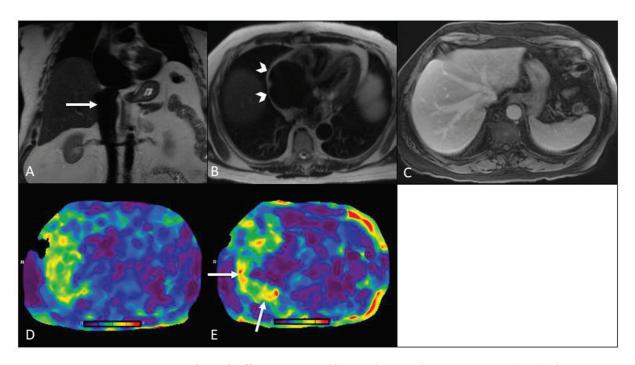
Passive venous congestion causing elevated stiffness. A 70-year-old man with tricuspid regurgitation. T2W (A, B) and postcontrast T1W (C) images show dilated IVC (arrow in A), right atrium (arrowheads in B) and dilated hepatic veins (C). MRE (D, E) shows elevated stiffness (mean 3.9 kPa). Notice predominantly peripheral increase of stiffness (arrows). Biopsy showed no fibrosis. IVC, inferior vena cava; MRE, magnetic resonance elastography; T1W, T1-weighted; T2W, T2-weighted.
